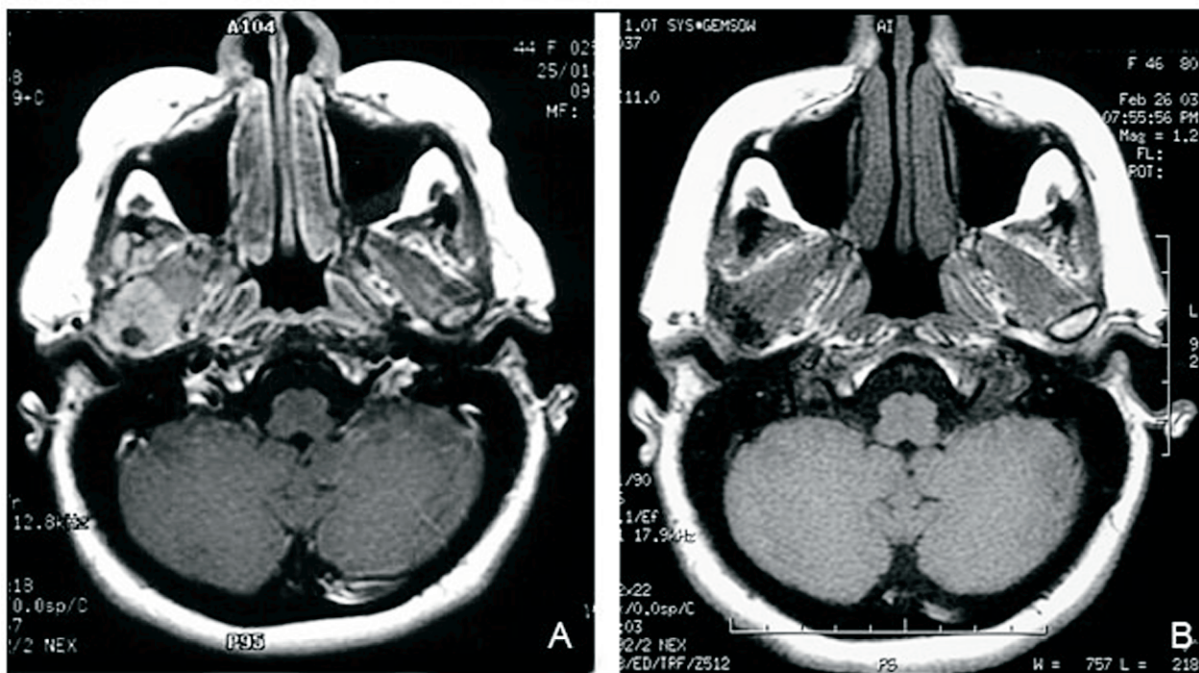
A. A MRI T1 W revealed an intermediate signal intensity in the vertical ramus, coronoid, and condylar processes with an expansile lesion in the sphenoid bone and the lateral orbital contour. B. MRI revealing a stationary lesion.
